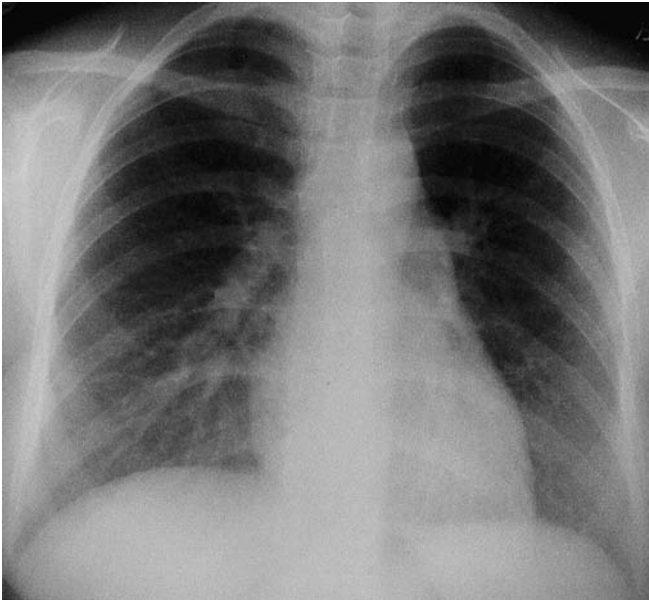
Patient's chest roentgenogram on admission. No abnormalities appear in the lung field
